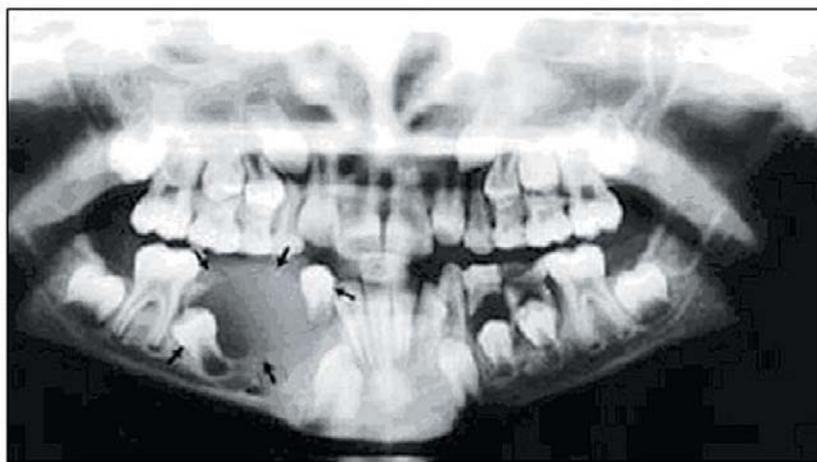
Panoramic radiography of CGCG causing tooth displacement in the mandibular incisor-premolar area.
